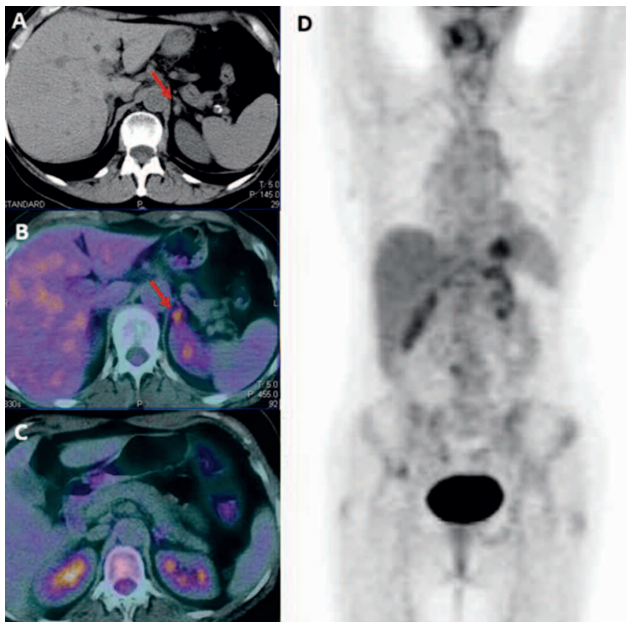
A 54 years old female with left primary adrenal non-Hodgkin's lymphoma. Computed tomography transaxial image A) showed a not well characterizable left adrenal lesion (red arrow). Fluorine-18-FDG PET/CT fused transaxial image B) showed ^{18}F -FDG uptake (SUVmax 4.8) in the left adrenal gland. Fluorine-18-FDG PET/CT fused transaxial C) and PET MIP D) images performed after chemotherapy, showed the resolution of the disease.
